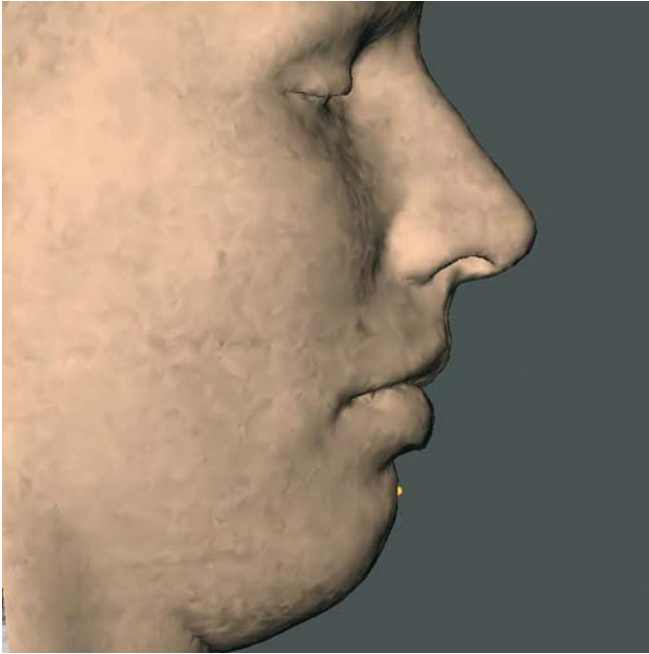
Soft tissue pogonion. Profile view right (3-D CT, patient K.C.)
